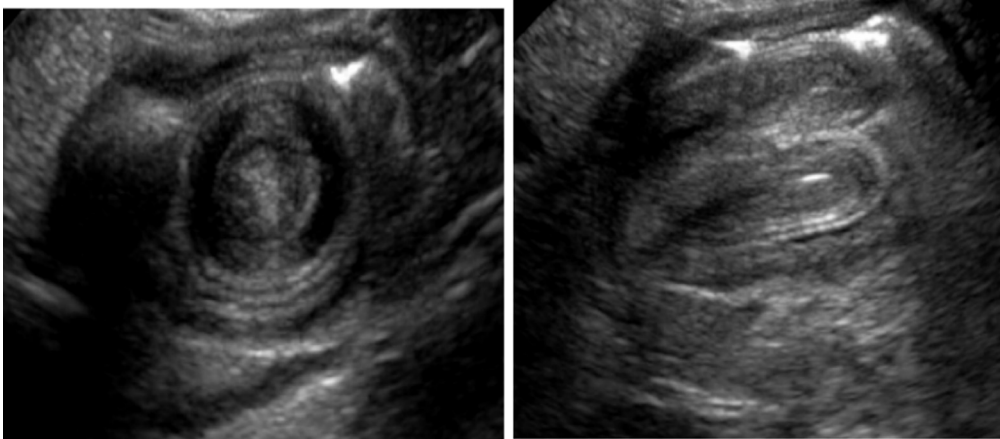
Sonographic picture consistent with intussusception.
